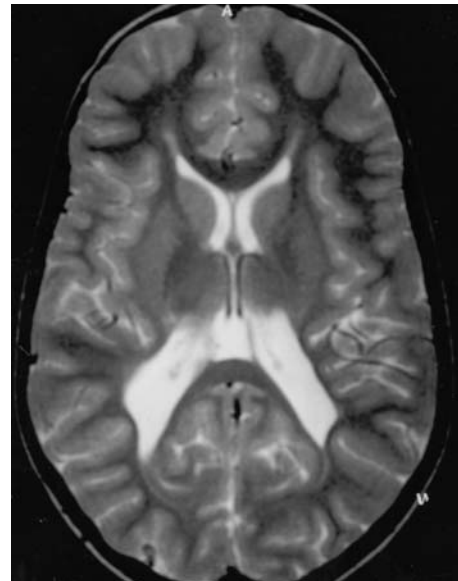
Axial T2-/FSE MRI. Follow-up examination of an 8-year-old girl, born prematurely (28 weeks). Clinically marked tetraspasticity. Periventricular leukomalacia with reduced bulk of white matter, irregular dilatation of posterior lateral ventricles, and T2 hyperintensity of central occipital and frontal white matter
